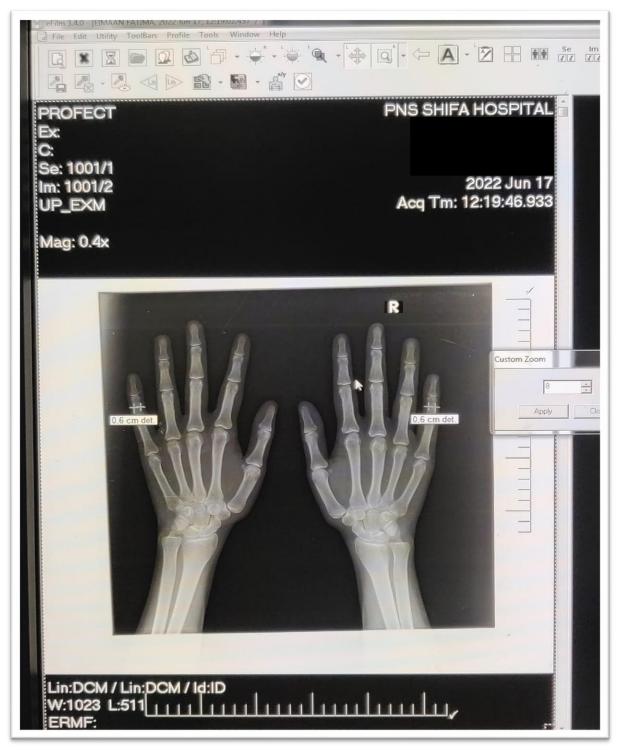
X-ray image of both the hands of another subject. The thickness of the middle phalanges of 5th digits have been marked and measured at their visible narrowest thickness.
